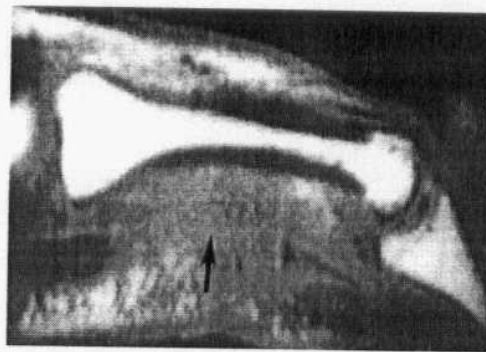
T1-weighted sagittal image show Complete disruption of the flexor digitorum superficialis and profundus tendons (arrow) are seen (Quoted from Stoller and Brody, 1997).
